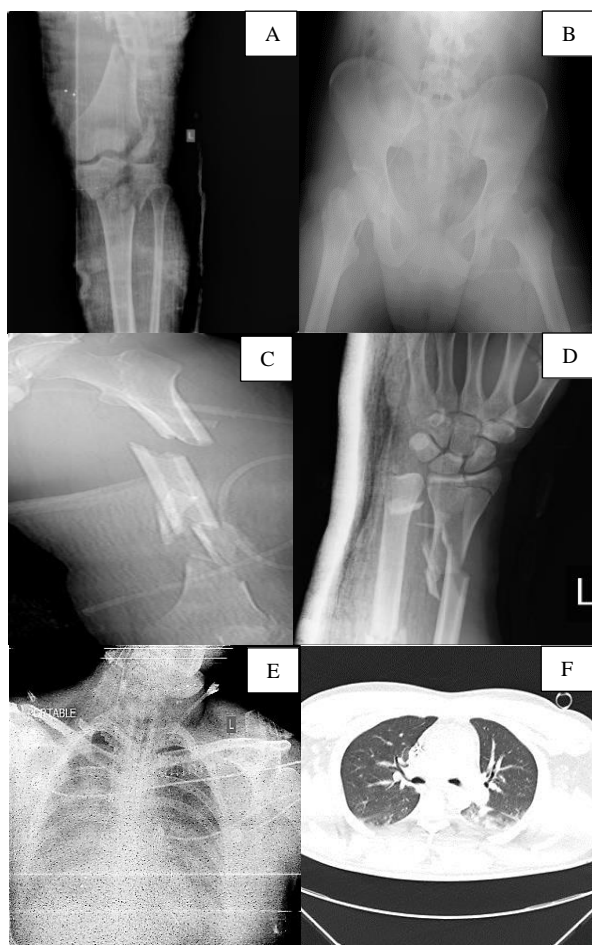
Case 5: A-D) preoperative radiographs of the patient, E) portable chest X-ray, F) chest computed tomography (CT) scan
